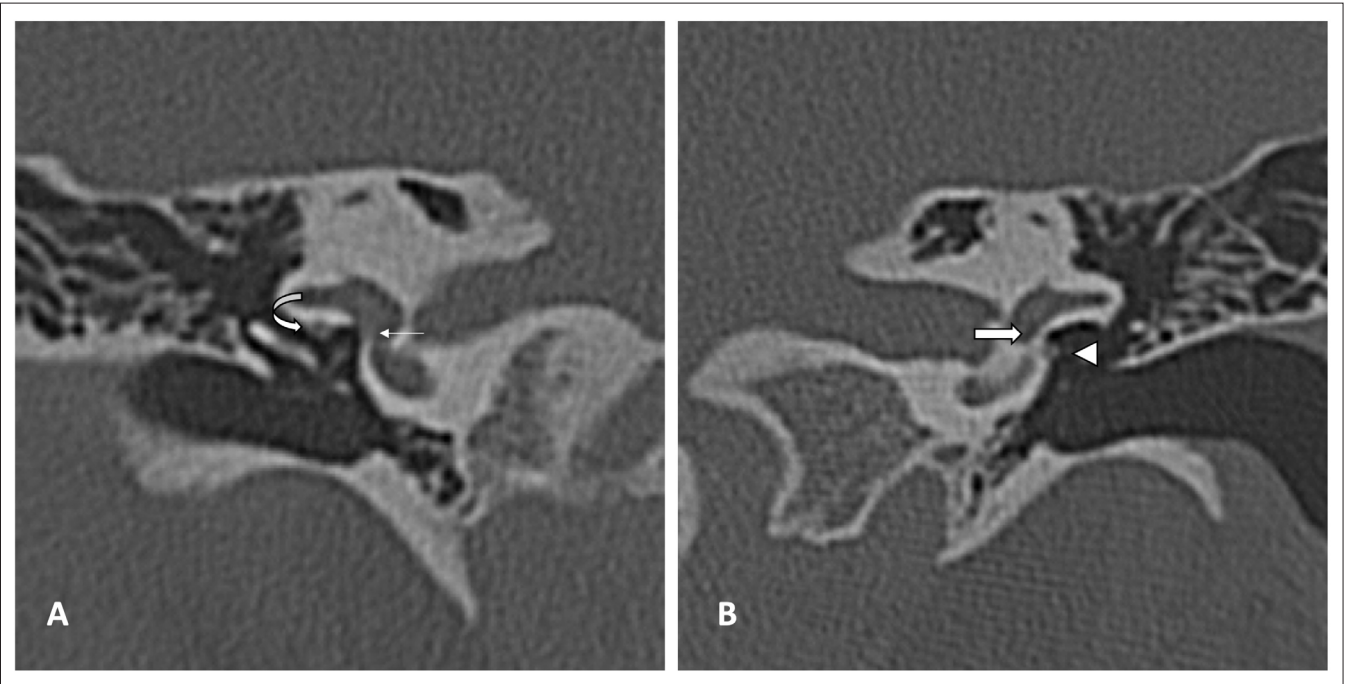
HRCT coronal images of Patient D with left oval window atresia, inferiorly displaced facial nerve and dysplastic stapes. (A) Right ear: normal oval window (thin arrow) with normal position of the facial nerve canal (curved arrow). (B) Left ear: absence of the normal oval window at its expected location (arrow). The facial nerve is displaced inferiorly, located just below the oval window niche (arrowhead).
